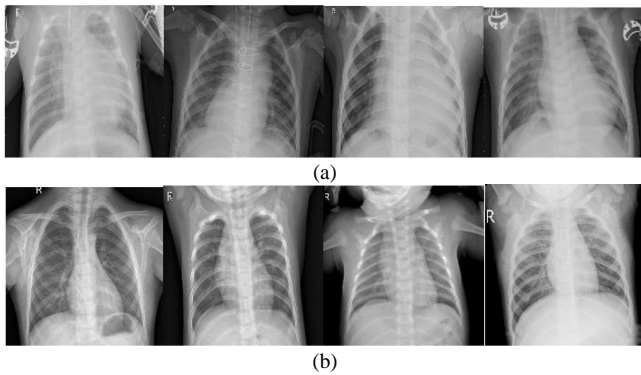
Sample X-Ray Set (a) Pneumonia, (b) Normal.
